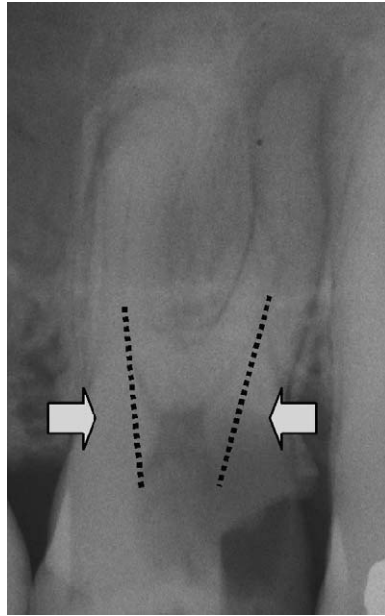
Straight line access on radiograph. Dotted lines and arrows indicate areas of dental overhang to be removed.
